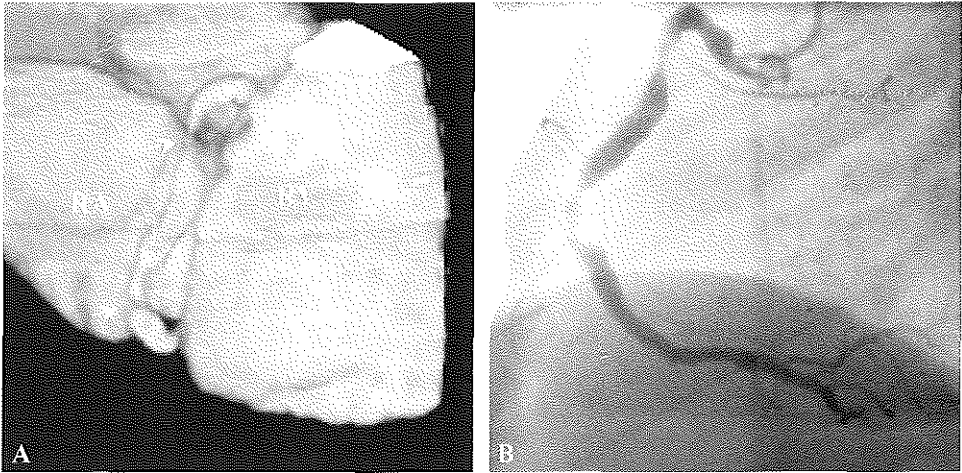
(A) Magnetic resonance imaging. Detailed view on the right coronary artery in the atrioventricular groove between the right ventricle (RV) and atrium (RA). The arrows indicate stenoses in the proximal and mid segment. (B) Corresponding conventional coronary angiogram.
